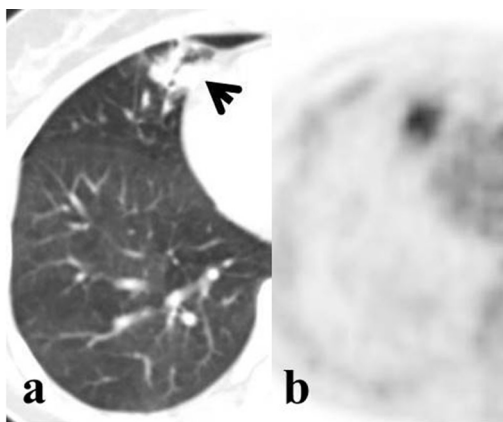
Axial ^{18}F -FDG PET/CT images of a 47-year-old female patient with a solitary LPA. a) CT image (lung window) showing a 25-mm-sized lobulated and spiculated nodule containing internal air densities in the right lung (arrow). b) PET image demonstrating ^{18}F -FDG uptake in the nodule with an SUV_{max} of 2.29
